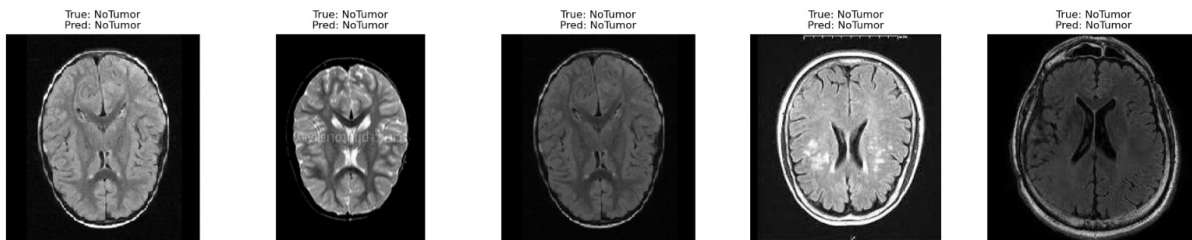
Visualization of MRI images for a tumor-free classroom with model predictions.
